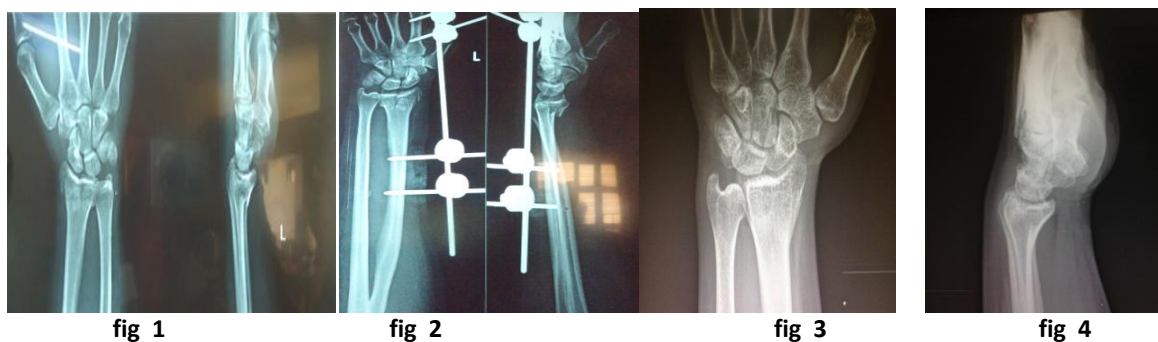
pre-operative radiograph showing Type III Frykman's classification. fig 2: post operative radiograph with external fixator insitu. fig 3 & 4 : follow up radiograph after 12 months.
